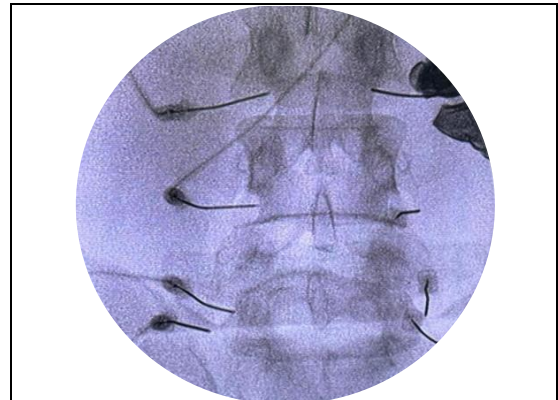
Anteroposterior radiography of the lumbosacral column.
